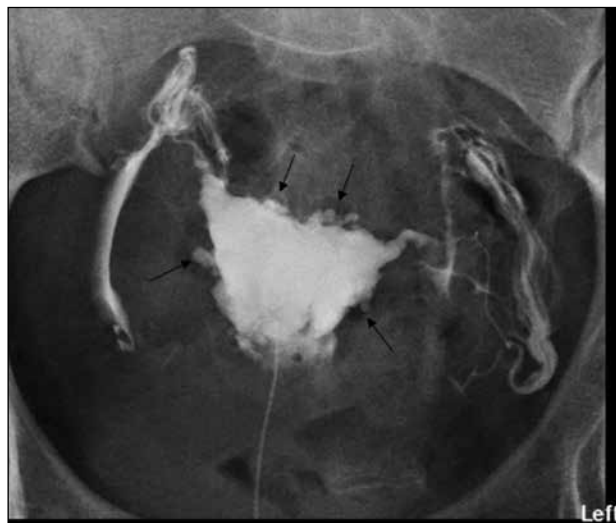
A 32-year-old woman with menstruation-related cavity changes mimicking diffuse adenomyosis. Hysterosalpingography (HSG) was performed at day 6 of menstruation. Irregular uterine cavity with multiple small contrast-filled outpouchings (arrows) are evident. Subsequent pelvic ultrasound showed unremarkable uterus without features of adenomyosis. No history of dysmenorrhoea was reported. Performing HSG during menstruation may result in diagnostic errors as cavity changes during menstruation may mimic diffuse adenomyosis.
